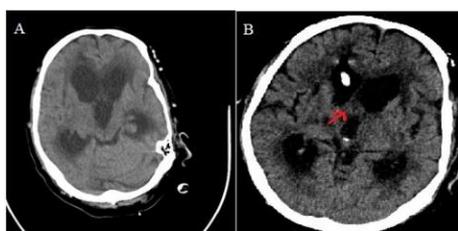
A and B) the non-contrast enhanced CT showing significant resolution of brain edema after insertion of the ventricular draining catheter. Left unilateral ventriculomegaly is noted with displacement of the septum pellucidum. An isodense mass is noted at the septum just posterior to the foramen of Monro (the red arrow)
